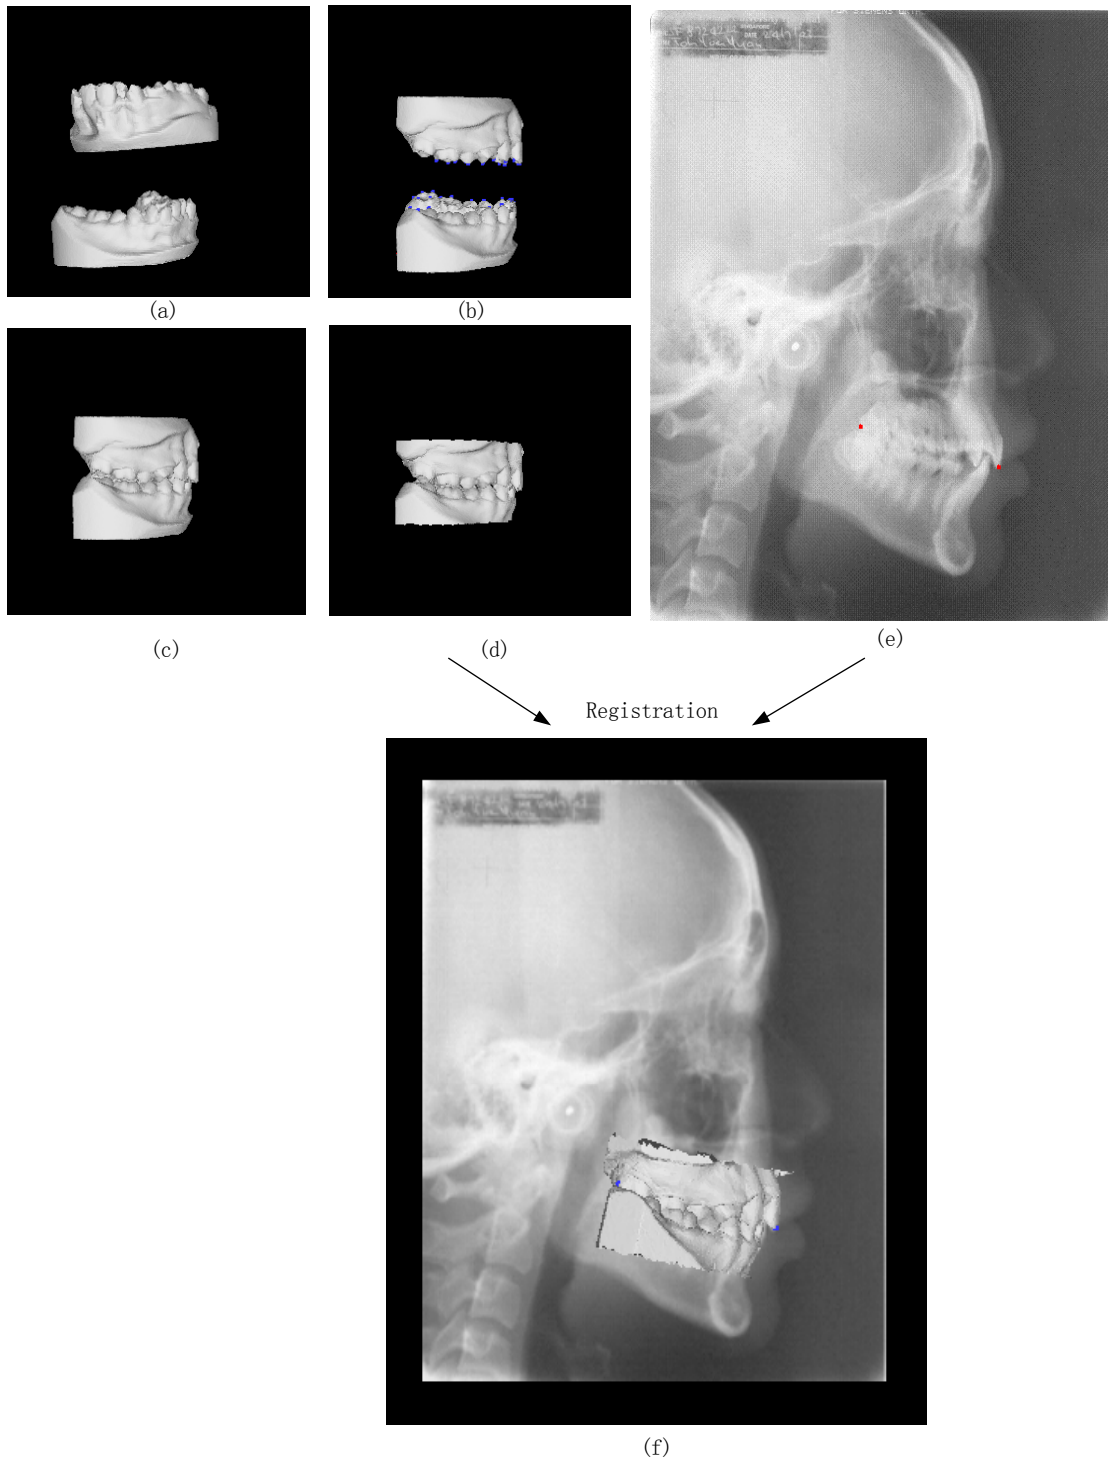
The entire process of registration between dental casts and cephalogram. Dental casts: (a) Initial position; (b) After rotation; (c) After translation; (d) Trimmed casts with landmarks. (e) X-ray with landmarks. (f) The registration result of dental casts with X-ray
